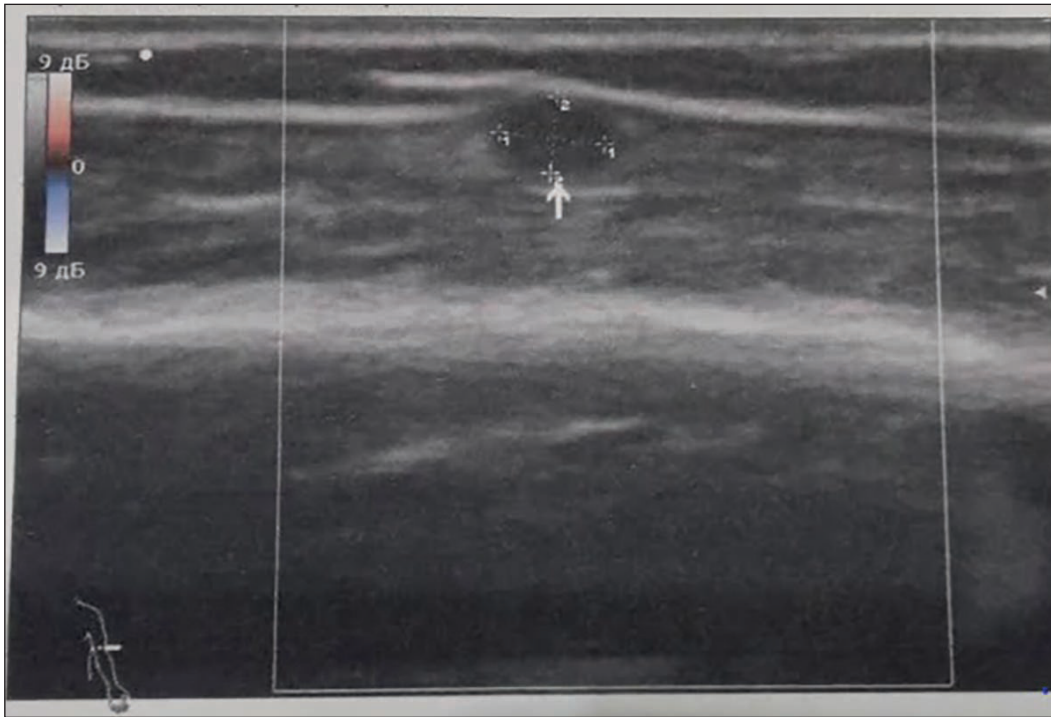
Ultrasound of shoulder neurilemmoma, showing a hypochoic encapsulated formation
